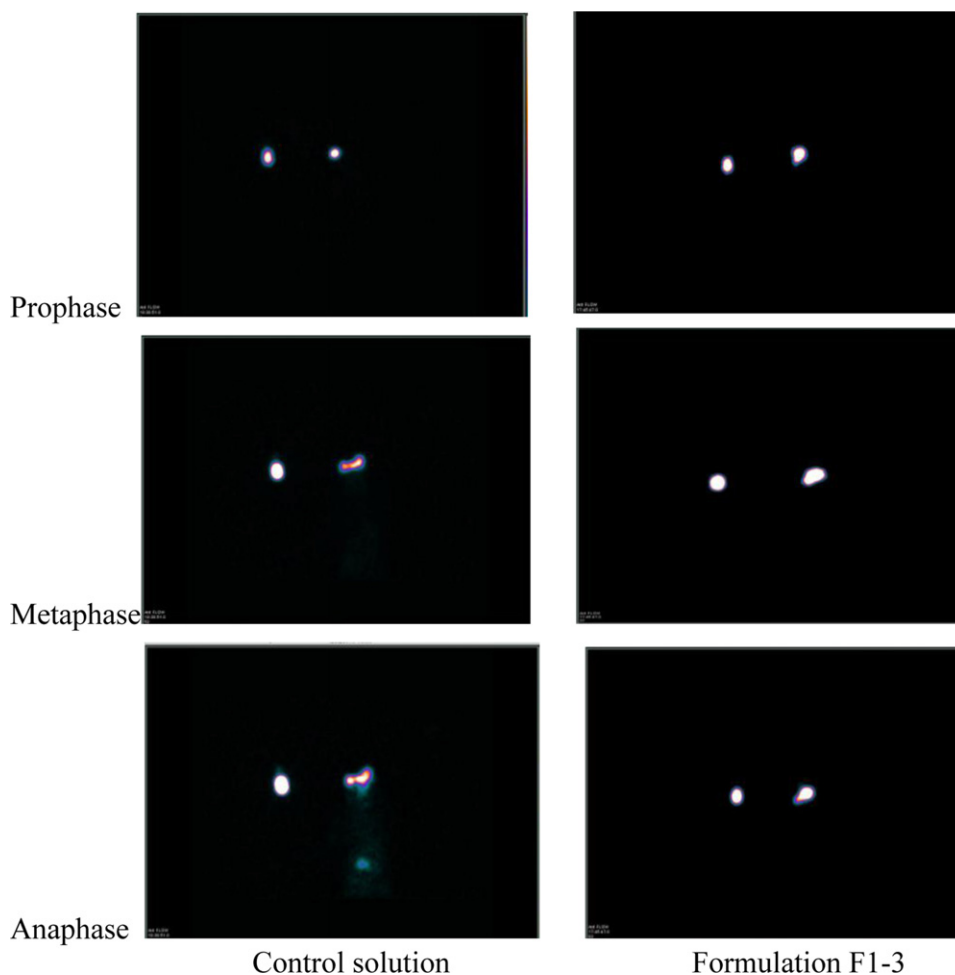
The comparison of the scintigraphic images between the control solution and formulation F1-3.
